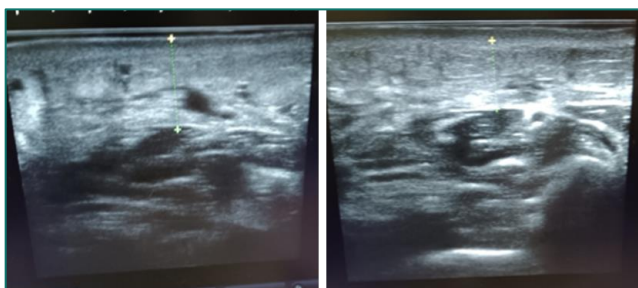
Ultrasonographic measurement of affected limb (a) without compression, (b) with compression
